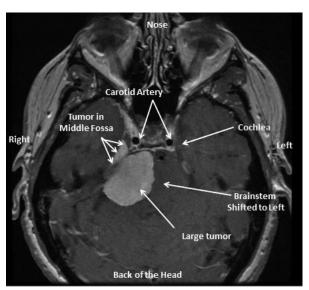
Axial (horizontal) T1 post-gadolinium MRI of the brain demonstrating a large mass in the right cerebellopontine angle. There is an extension into the middle fossa.
